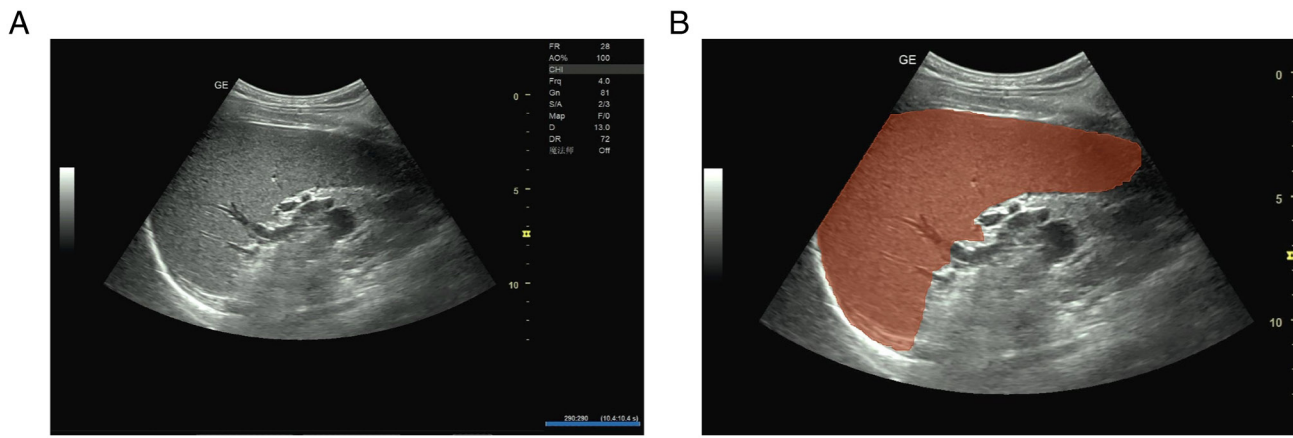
ROI target volume delineation on spleen ultrasound images. (A) Original grayscale ultrasound image showing the maximum long-axis section of an enlarged spleen in a patient with myelofibrosis. The spleen boundaries are clearly visible with homogeneous echotexture. (B) The same image with manual ROI delineation (orange overlay) performed by an experienced sonographer, encompassing the entire splenic parenchyma while carefully excluding surrounding structures. The ROI covers 95% of the visible spleen area, avoiding edge artifacts and adjacent organs. Scale bar, 5 cm. ROI, region of interest.
